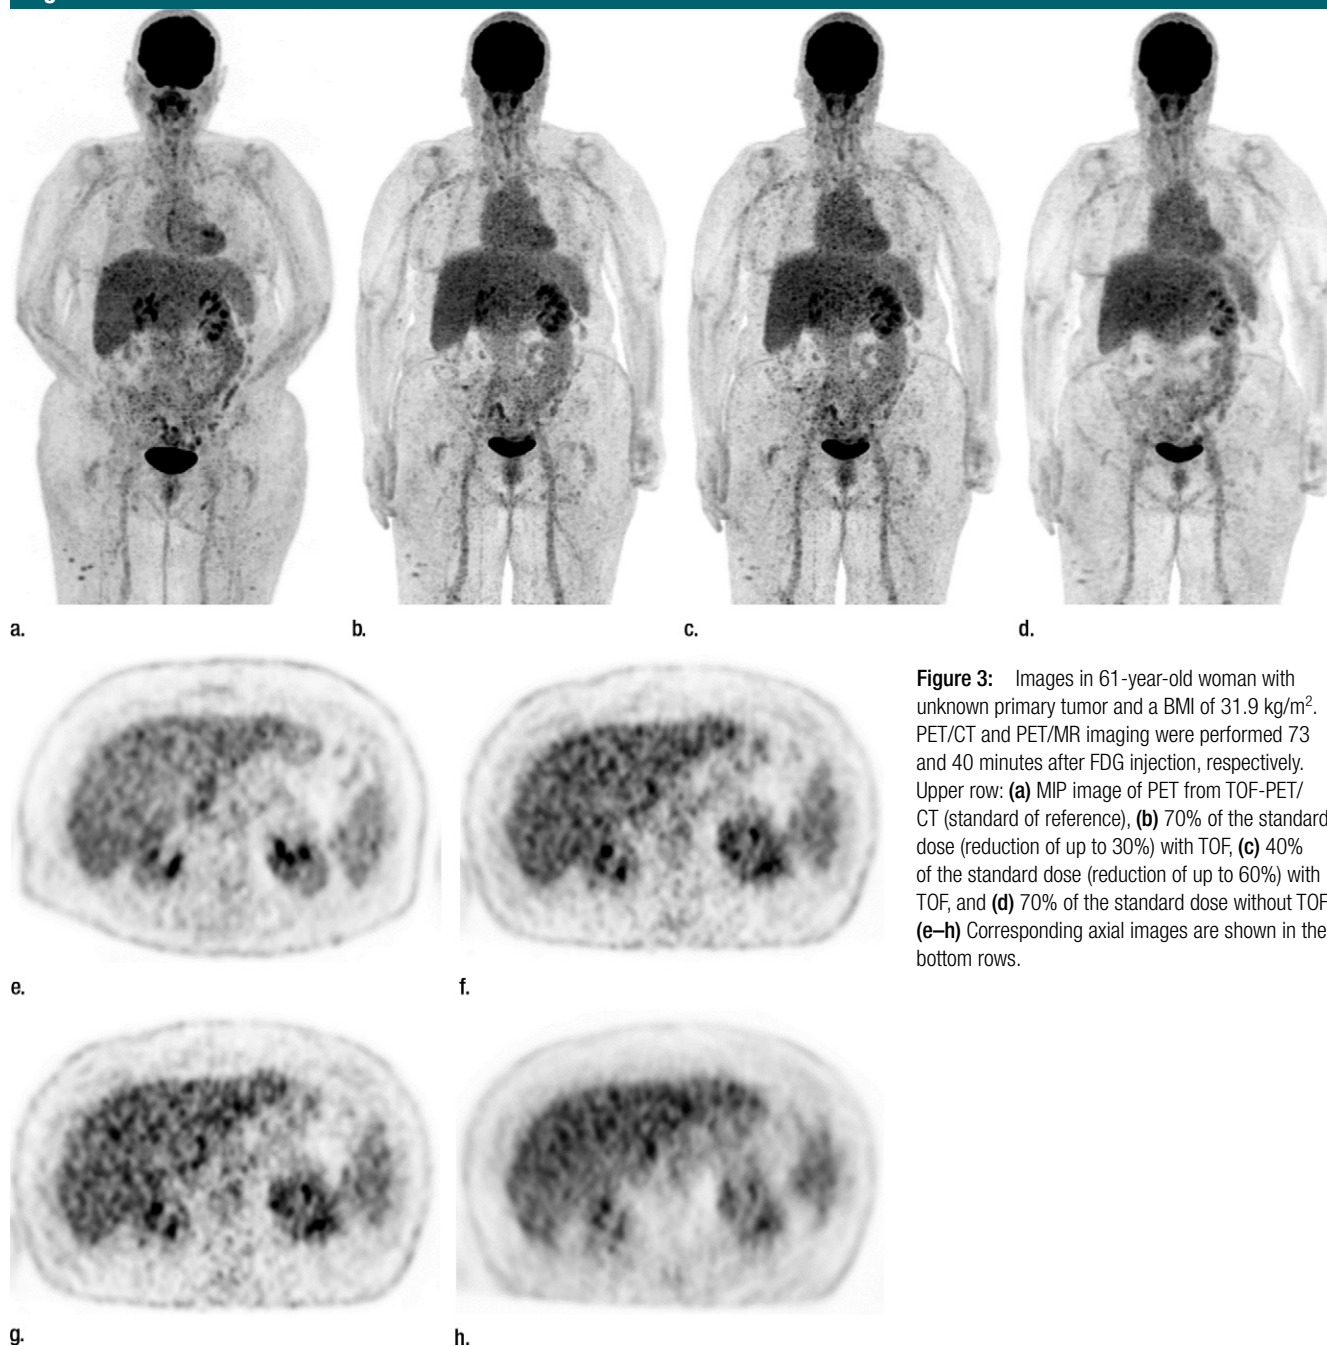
Images in 61-year-old woman with unknown primary tumor and a BMI of 31.9 kg/m². PET/CT and PET/MR imaging were performed 73 and 40 minutes after FDG injection, respectively. Upper row: (a) MIP image of PET from TOF-PET/CT (standard of reference), (b) 70% of the standard dose (reduction of up to 30%) with TOF, (c) 40% of the standard dose (reduction of up to 60%) with TOF, and (d) 70% of the standard dose without TOF. (e–h) Corresponding axial images are shown in the bottom rows.
